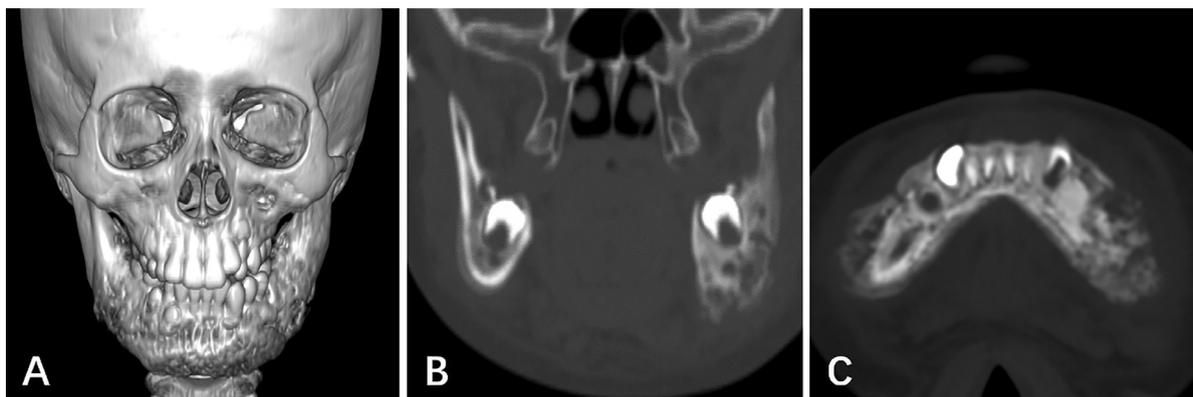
Computed tomography (CT) images before drug therapy, showing hypertrophy and deformity of the mandible, as well as coarse bone cortex and sclerosis of the cancellous substance.
